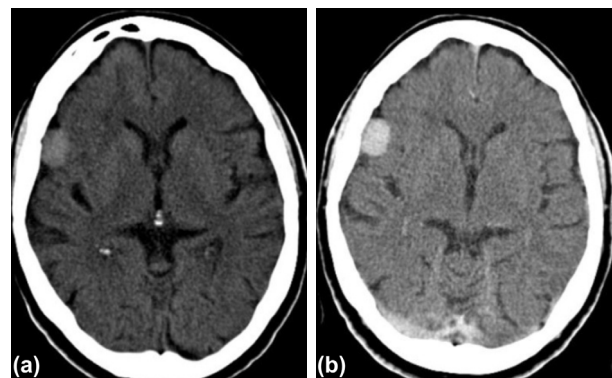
(a) CT scan hyperdense mass in the left temporal region; (b) After contrast, there is a homogeneous enhancement of the mass. CT: Computed tomography.
